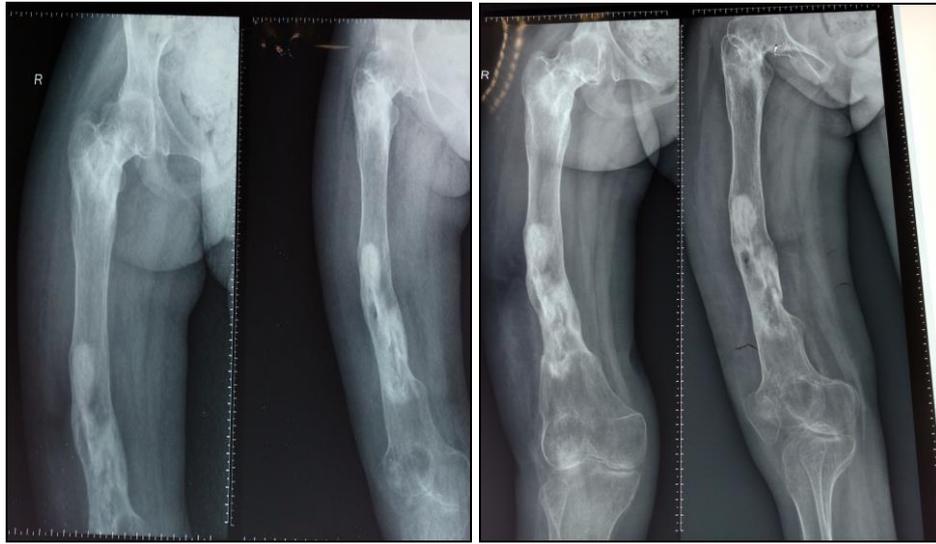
Serial radiographs of a 12-year-old showing diaphyseal chronic osteomyelitis of femur with increased sclerosis and cloaca formation which gradually progressed to reduce sclerosis as well as healing of the cloaca gradually with no evidence of any pathological fracture.
